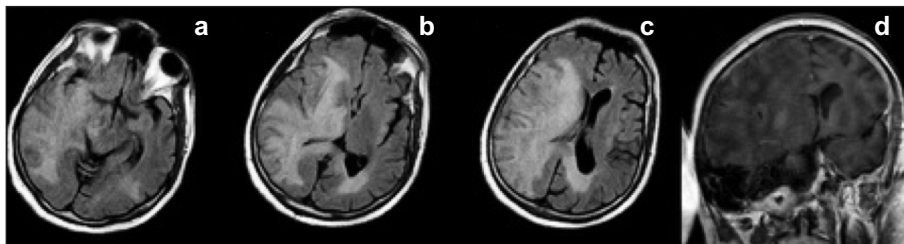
Magnetic resonance imaging (MRI) scans obtained at the onset of the symptoms (April 30, 2014); axial fluid-attenuated inversion recovery (FLAIR) images (a,b,c) demonstrate abnormal focus of increased T2 signal involving right posterior parietal region, right capsula externa and capsula extrema, right thalamus, and left anterior frontal subcortical white matter. Axial T1 postgadolinium image (d) showed no gadolinium enhancement.
